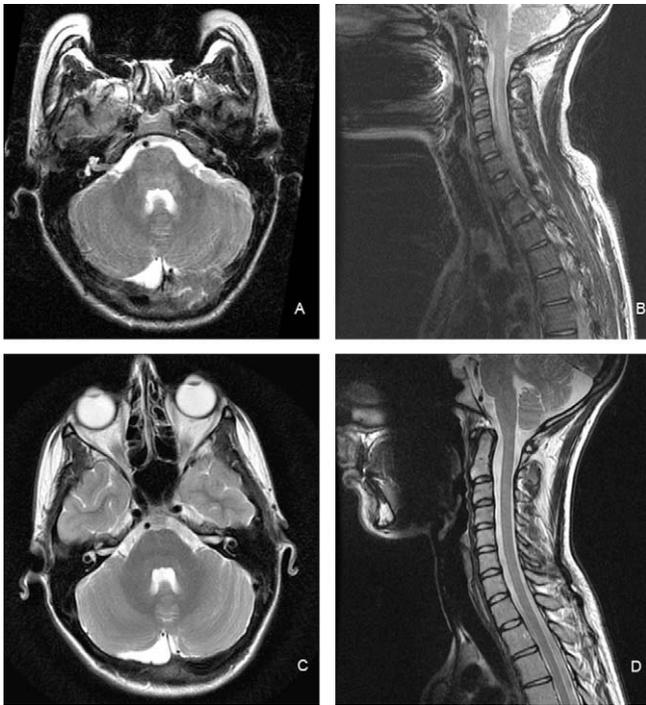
A T2-weighted MRI of the axial brain (A, C) and sagittal cervical spine (B, D). (A, B) High signal is seen in the pons extending into the left middle cerebellar peduncle and cervical cord. (C, D) A follow-up MRI six months later showing resolution of T2 signal changes.
